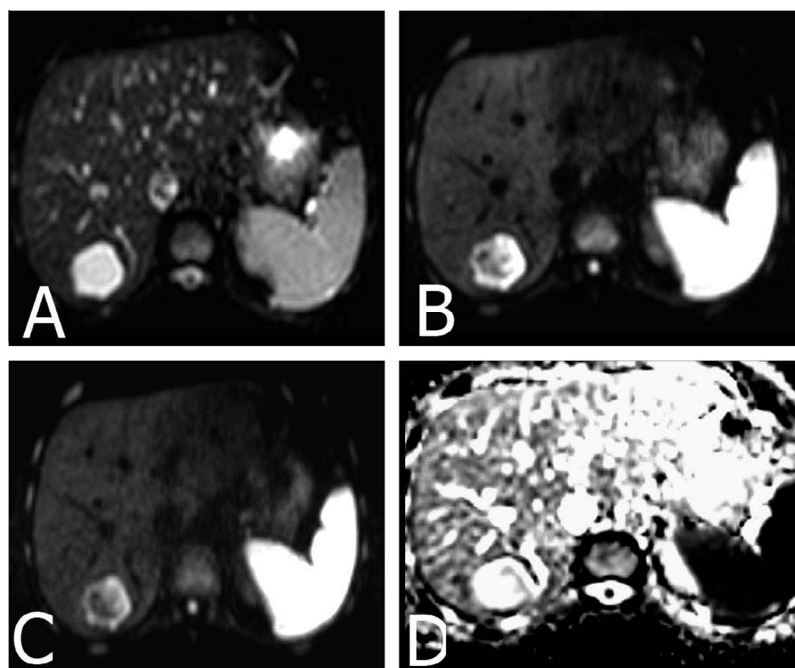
Diffusion weighted MR images of 42 year old male patient with hemangioma, DWI at b_0 (A), DWI at b_500 (B), DWI at b_{1000} (C) and ADC map (D) shows mixed high SI with high mean ADC value at $b_{1000} = 2 \times 10^{-3} \text{ mm}^2/\text{s}$.
